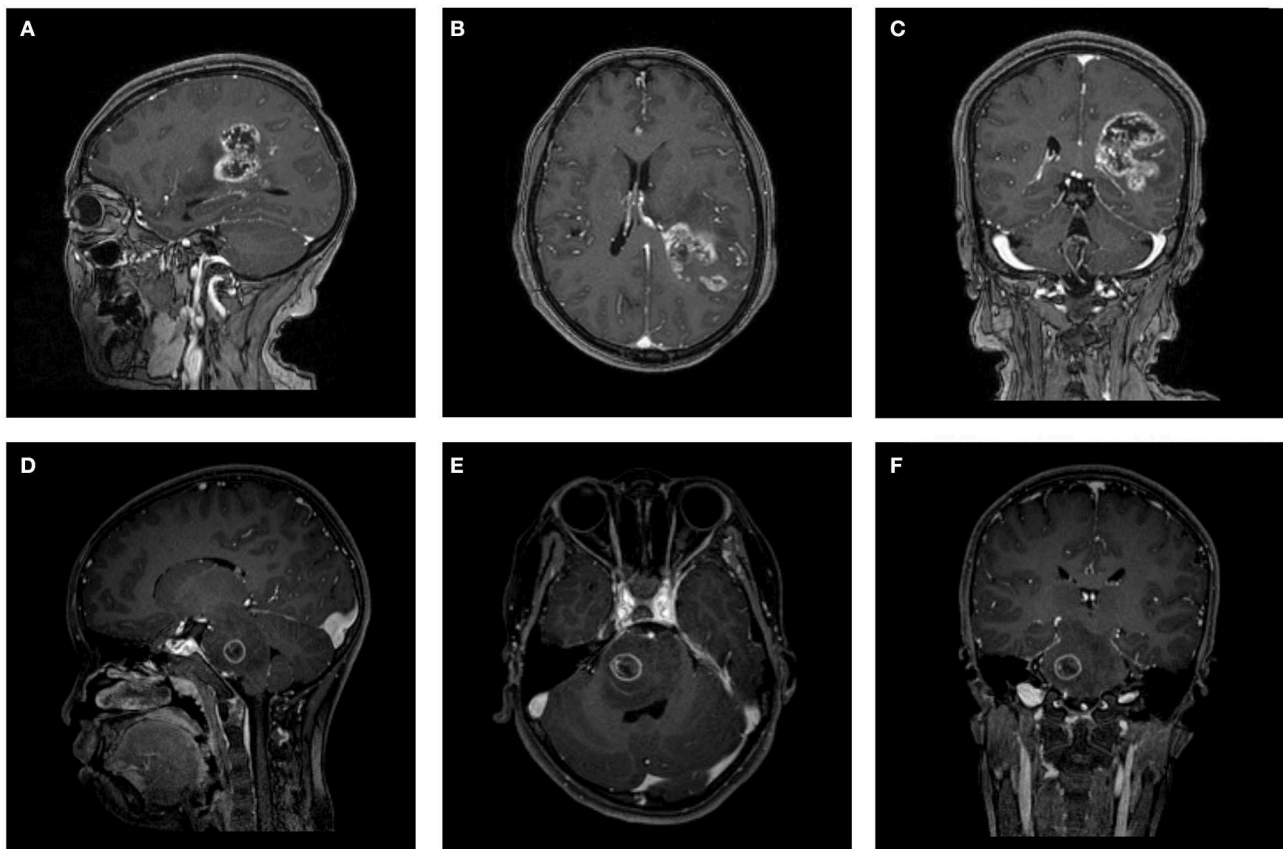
Two examples of contrast-enhanced MRI images. (A–C) Patient with GBM in (A) parasagittal, (B) axial, and (C) coronal view. (D–F) Patient with AO in (D) parasagittal, (E) axial, and (F) coronal view. GBM, glioblastoma; AO, anaplastic oligodendroglioma.
